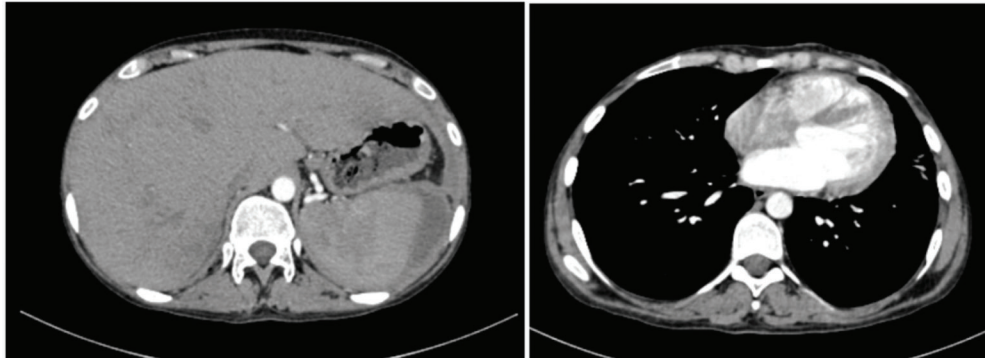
CT images at the end of first month (loss of abscess and effusions)
